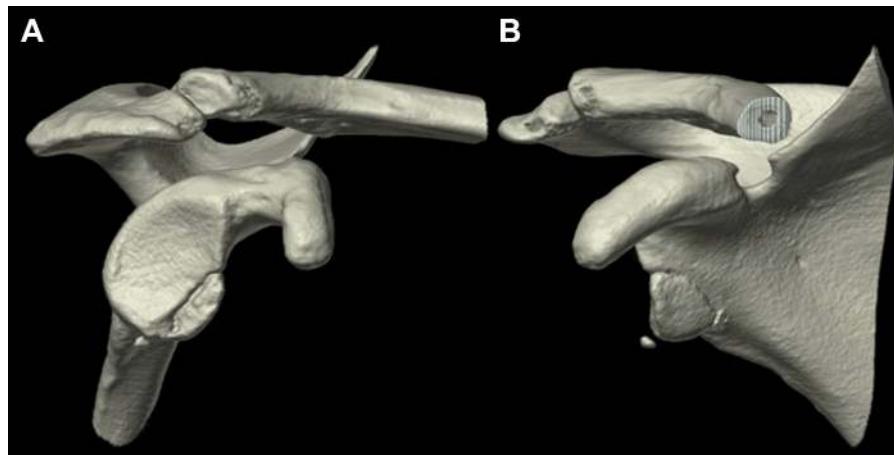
Three-dimensional CT reconstruction images of a right shoulder showing an anteroinferior glenoid bony Bankart lesion of approximately 20% to 25% of the glenoid width (A, viewed laterally; B, coronal cut, viewed from anterior aspect).
